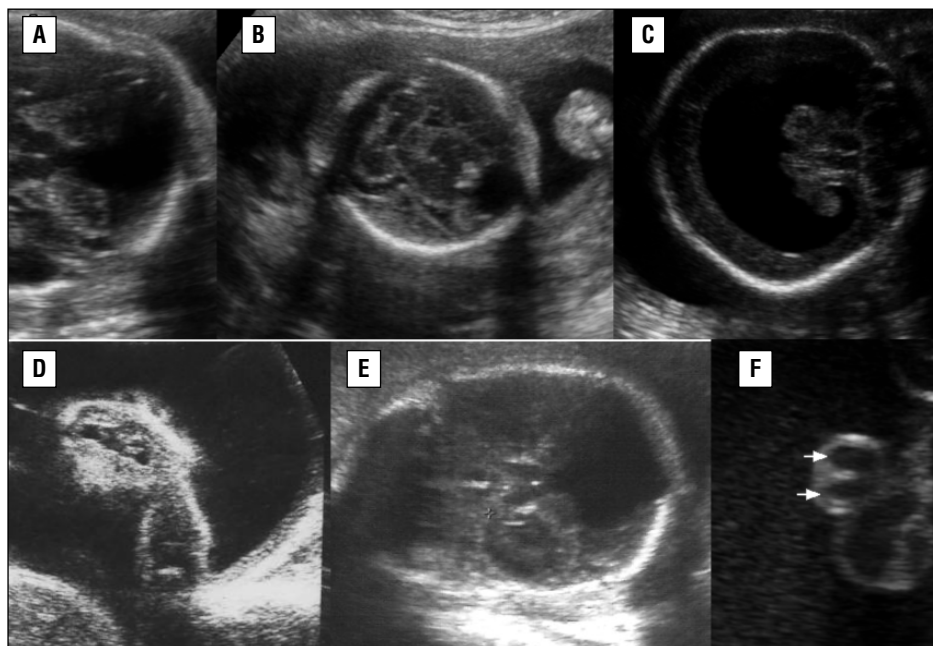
Ultrasound feature in cases with trisomy 13. A. Vermis agenesis; B. Semilobar holoprosencephaly; C. Alobar holoprosencephaly; D. Cleft lip; E. Dandy-Walker malformation; F. Single umbilical artery.
